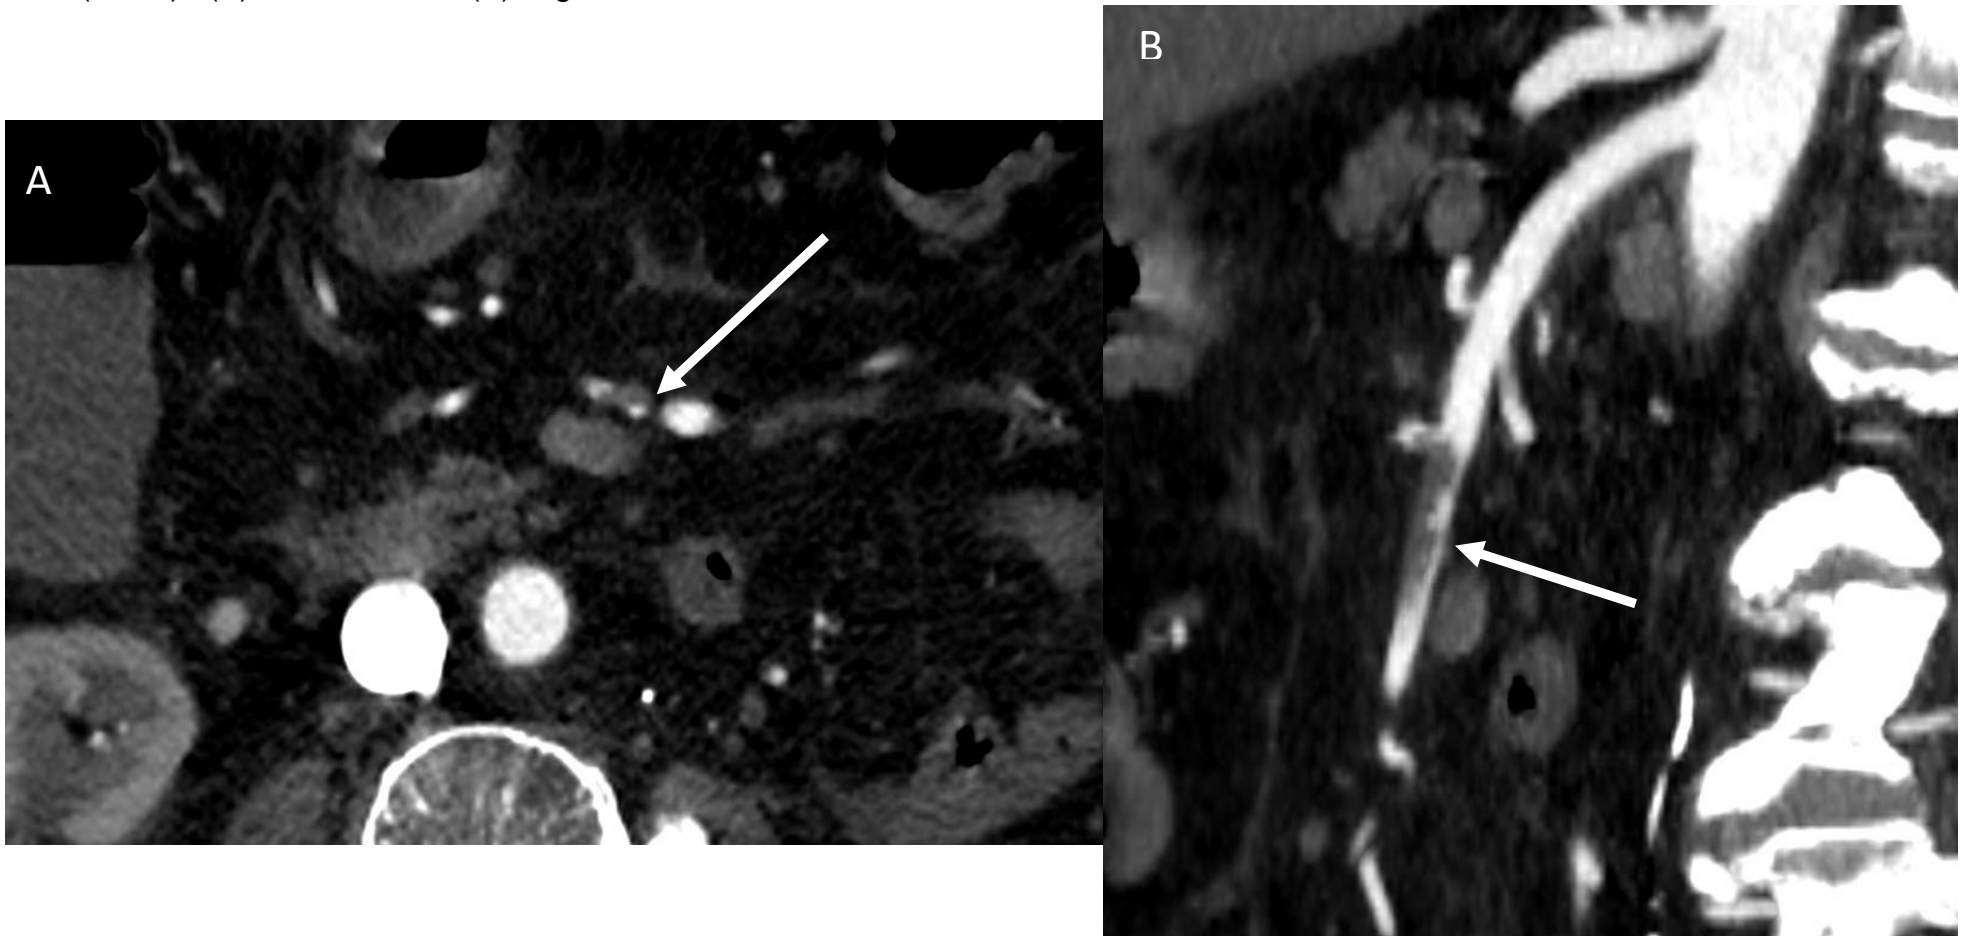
Abdominal CT-scan of a 45 years old patient with AMI showing an incomplete occlusion of the S1 segment of the SMA (arrow) : (A) coronal view and (B) sagittal view
